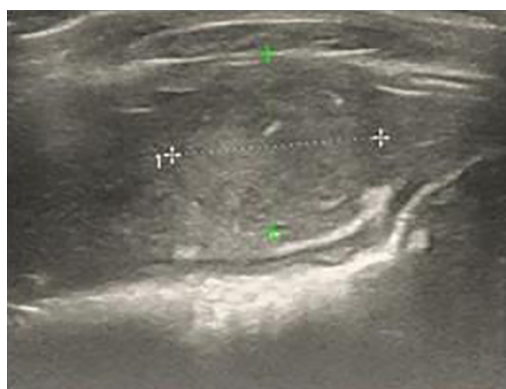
Preoperative two-dimensional ultrasound measurement of tumor size.
